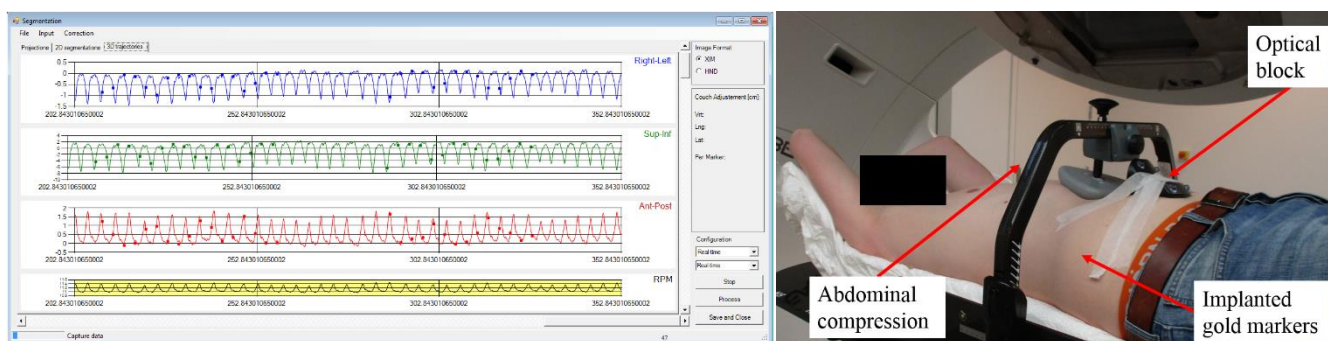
Left: Screenshot of the COSMIK user interface during a real-time patient treatment. The top three graphs represent the motion in each direction and the last graph shows the external optical block signal. The dots on the graph show the internal 3D marker position as determined every 3 s by intra-treatment x-ray images. Right: Patient setup for stereotactic liver radiotherapy with tumor motion monitoring by COSMIK.
